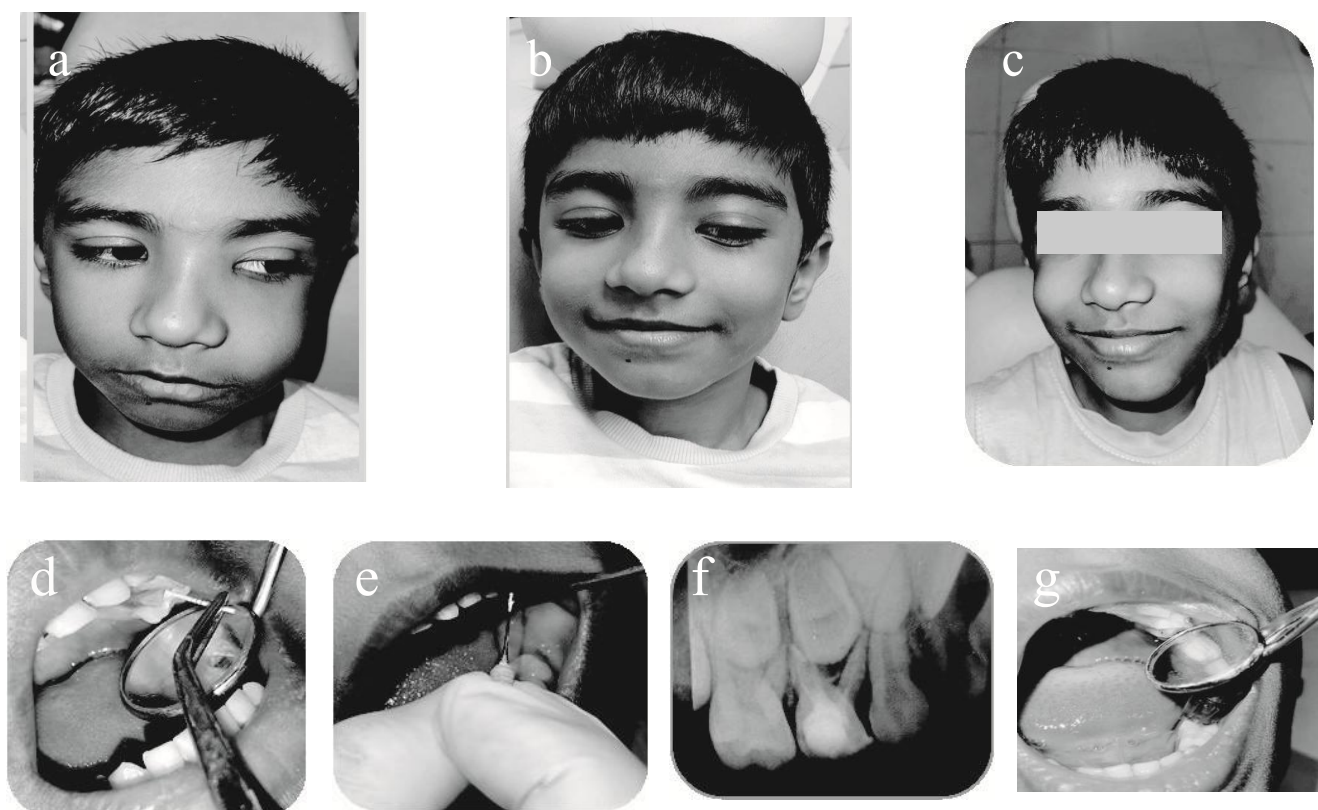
After calcium hydroxide a) Before, b) After, c) After seal 7 days follow, d) Dried the canal with paper point, e) Application of sealer into canal, f) Post Operative Radiograph (After seal) g) Final restoration with Glass ionomer cement
